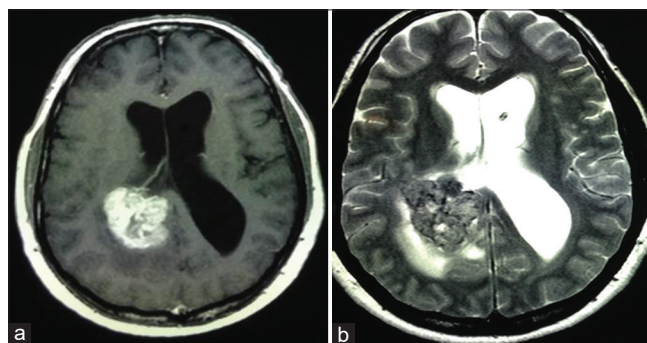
Axial (a) T1- and (b) T2-weighted MRI scans demonstrating a contrast-enhancing oval tumor located in the right lateral ventricle trigone causing obstructive hydrocephalus.
